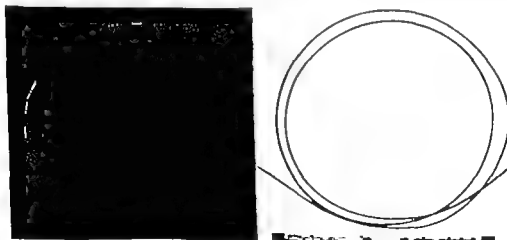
Left: Radiograph of measuring guide showing alternating radiopaque and radiolucent elements. Right: Photograph of measuring guide with centimeter ruler.
